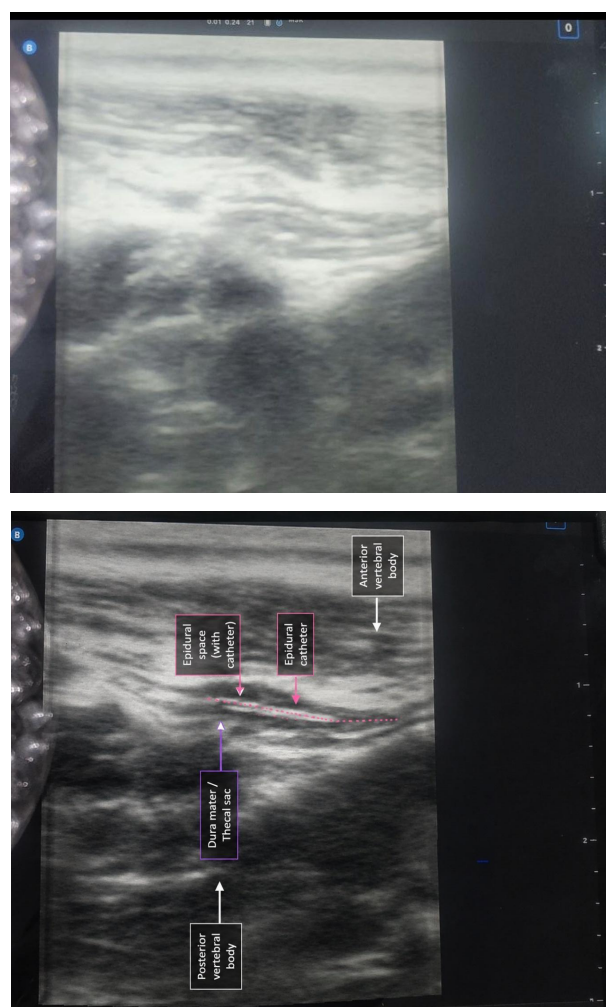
Ultrasound image of epidural catheter in situ.
